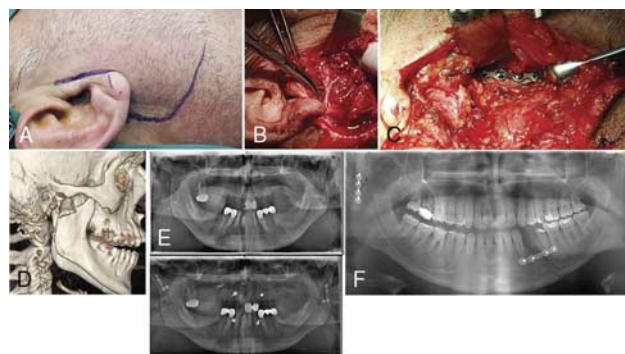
A, Intraoperative picture showing the modified Blair incision. B, Intraoperative picture showing the main trunk and branches of the facial nerve. C, Intraoperative picture showing rigid fixation of the fracture of the right mandibular condyle with 2 mm miniplate. D, Preoperative three-dimensional computed tomography image of the fracture of the right mandibular condyle. E, Preoperative and postoperative orthopantomography images of a bilateral fracture case. F, Postoperative orthopantomography image showing reduction of the fracture of right mandibular condyle.
